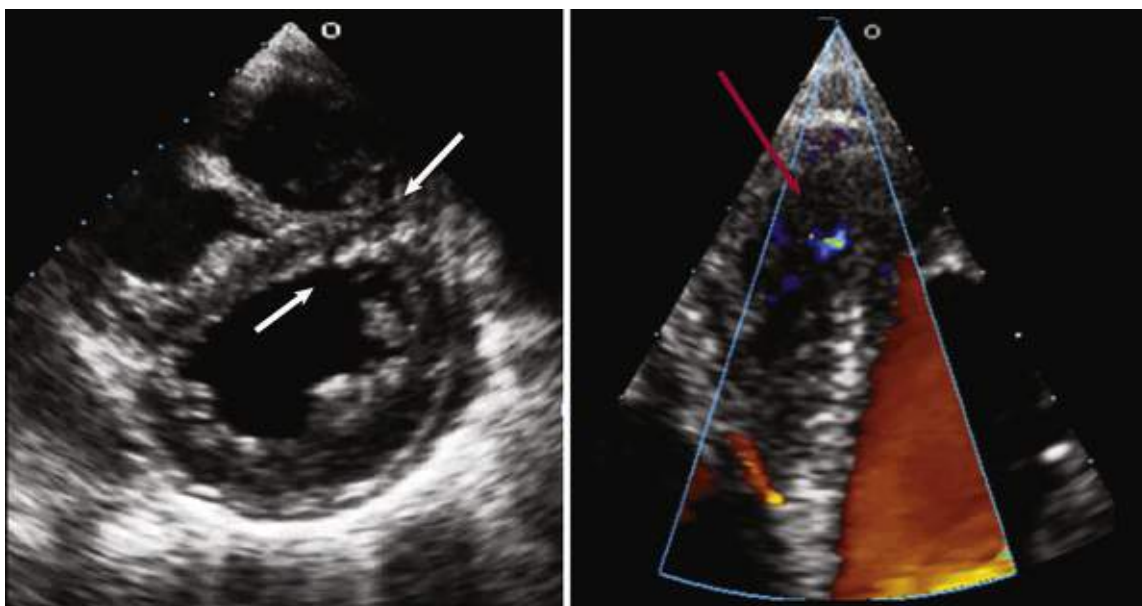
Parasternal short-axis (left) and off-axis apical (right) views demonstrating a serpiginous muscular VSD. The *white arrows* point to LV and RV entry points. The *red arrow* identifies a small left-to-right shunt.
